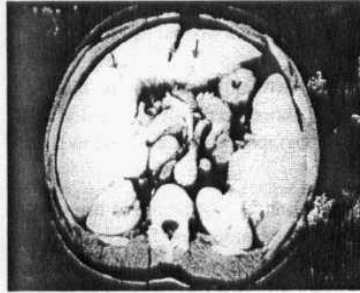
(a) CTAP showed uneven distribution of the contrast through the liver parenchyma, may cause considerable difficulty in interpretation. (b) On DS-CT this metastasis was correctly identified.
